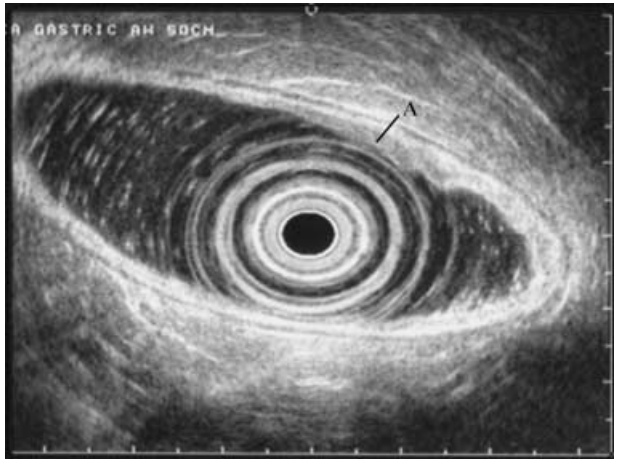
Endoscopic ultrasound appearance of T1 gastric cancer. There was thickening of the mucosal layer (A), with the submucosal layer (B) and the muscularis propria (C) remaining intact.
